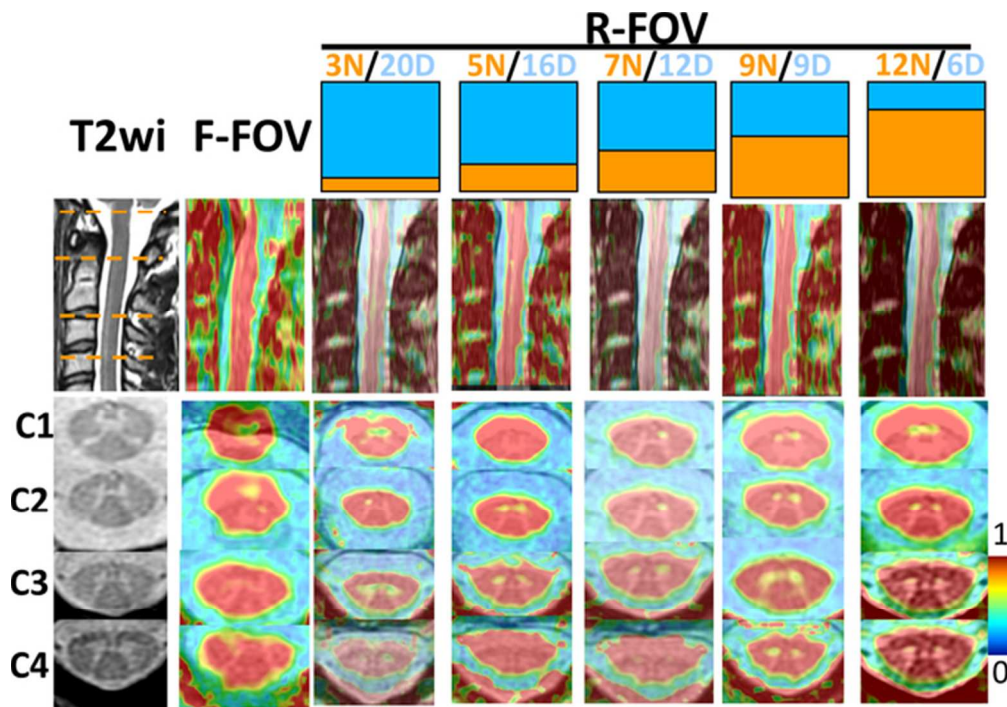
Examples of MR images available for qualitative analysis. All the images come from the same subject. Cervical levels are located on 3D T2-MERGE and sagittal T2-SE. Fusion of FA – 3D MERGE clearly exhibits that f-FOV DTI and r-FOV 3N/20D are more distorted, more blurred and with less anatomical precision than the other r-FOV.
